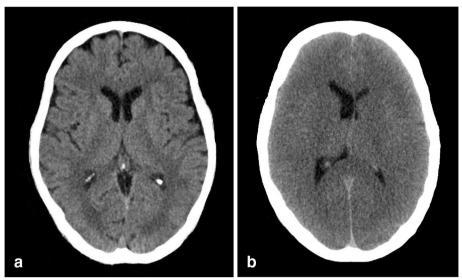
CT brain images showing; a normal CT brain from a 70-year-old man. b CT brain 40 h post-arrest in a 48-year-old man. Note generalized oedema with sulcal effacement, ventricular narrowing and reduction of the grey-white matter differentiation
